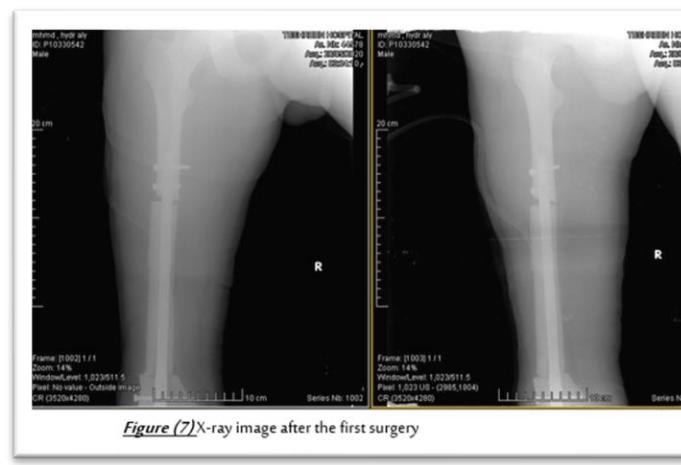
X-ray image after the first surgery
